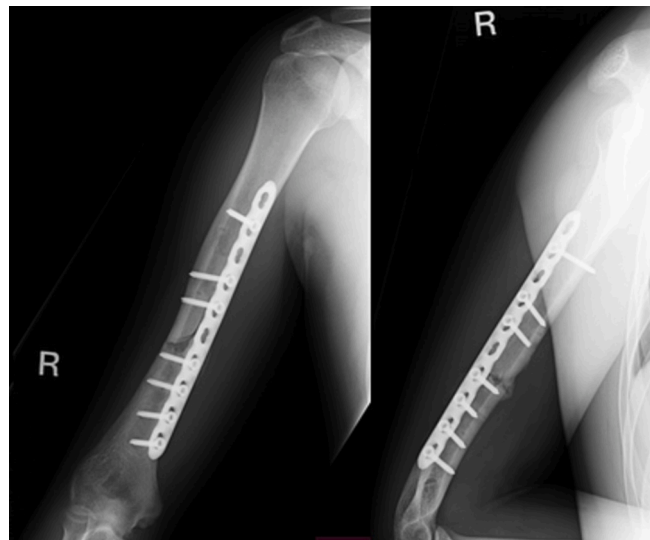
Radiograph of right upper arm at 3 months postoperatively.
